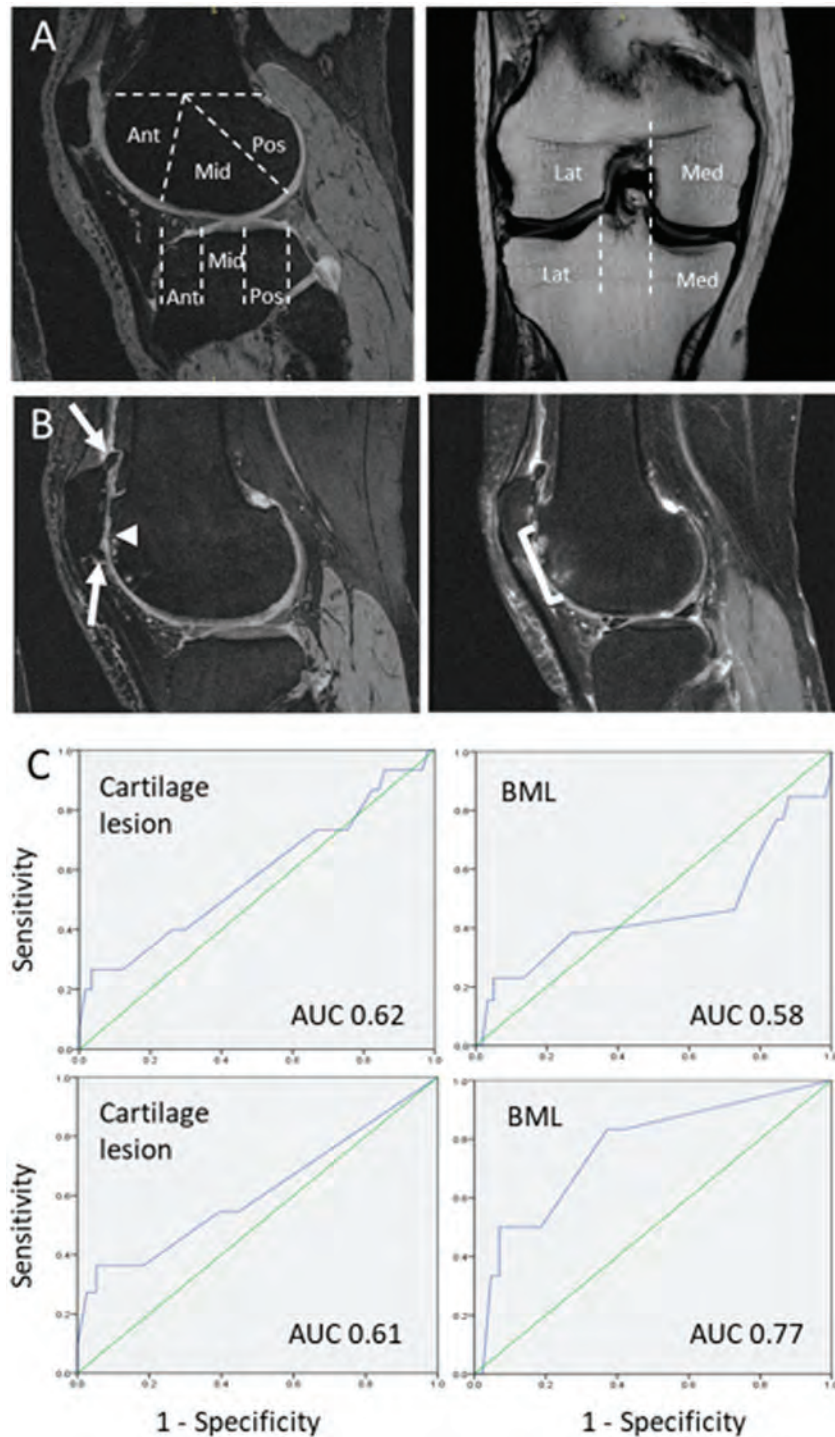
Structural changes associated with knee extension loss. (A) Left: Regional knee division of the MRI Osteoarthritis Knee Scoring system. Cartilage and bone marrow lesions were evaluated in the patellar, anterior (ant) and middle (mid) femoral, and anterior tibial regions where they could limit knee extension via pain inhibition. Osteophytes were evaluated in the patellar, anterior and middle femoral and anterior tibial regions where they could mechanically limit knee extension. Meniscal lesions were evaluated in all regions, as any “locking” from meniscal tears could limit knee extension. Right: Corresponding coronal sections where medial and lateral regions were investigated. (B) MRI of a participant with knee flexion contracture Left: Dual echo steady state sequence showing thinner articular cartilage in the antero-lateral femur making up the femoral side of the patellofemoral joint (arrowhead) and patellar osteophytes (arrows). Right: T2-weighted image with bracket showing large BML in the antero-lateral femur. (C) Receiver-operator curves for the presence of cartilage lesion (left) and bone marrow lesion (BML, right). Top: All participants KL 0-1 (n=596). Bottom: KL 0-1, excluding knees with hyperextension (n=49). Ant: anterior; AUC: Area under the curve; Med: medial; Lat: lateral; Mid: middle; Pos: posterior.
